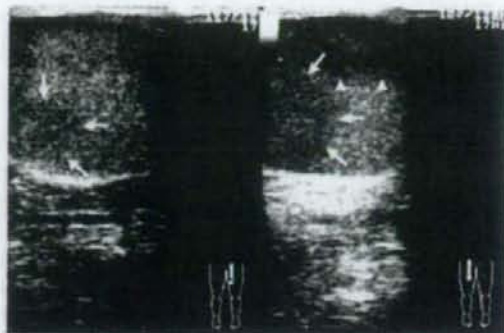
Ultrasonographic views of the right (left) and left (right) testes (sagittal plane) demonstrated hypoechoic lesions in the testicular parenchyma (arrows), suggesting sarcoidosis. Another hypoechoic area (arrowheads) was an artefact.
